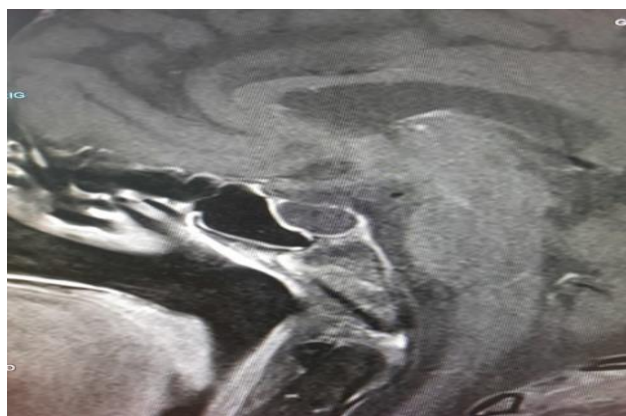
MRI showing empty sella.
